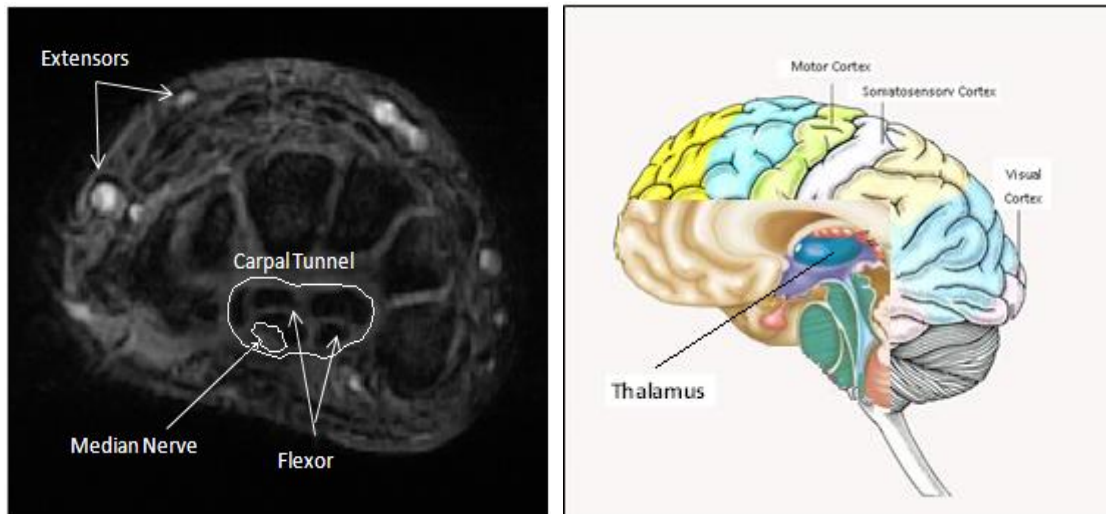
14 shows the ROIs, left shows the median nerve in the carpal tunnel on an axial MRI image. Right shows the ROIs in the motor sensory cortex and visual cortex (Joseph 2009).
